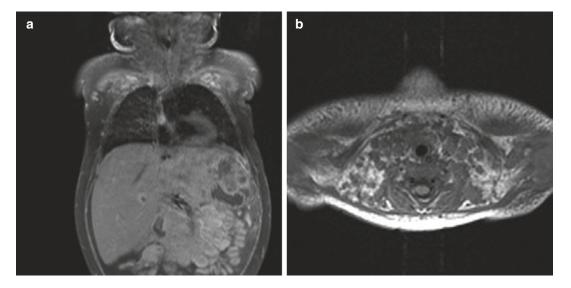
Extrarenal rhabdoid tumor. (a) Coronal T1-weighted MR image after gadolinium contrast injection. (b) Axial T2-weighted MR image. One-year old patient with a metastasized hepatic rhabdoid tumor and a
